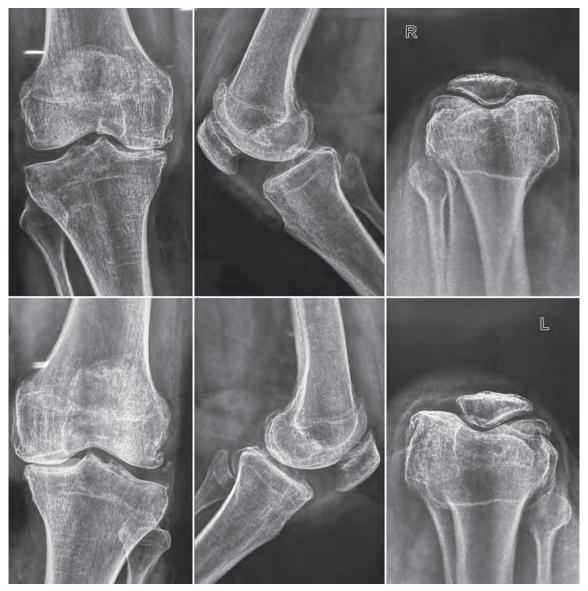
Preoperative standing anteroposterior, lateral, and skyline view X-rays of both knees
